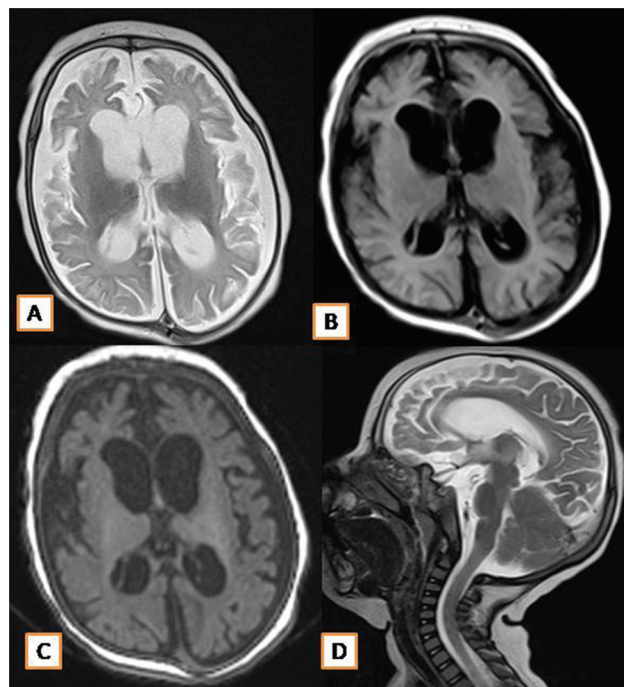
Magnetic resonance imaging brain axial T2-weighted imaging, T1-weighted imaging, fluid-attenuated inversion recovery, and sagittal T2-weighted imaging showing a loss of deep white matter volume evidenced by thinning of gyri and prominent sulcal spaces in bilateral cerebral hemispheres resulting in diffuse cerebral atrophy. Resultant dilatation of the ventricular system noted. There is severe thinning of corpus callosum.
